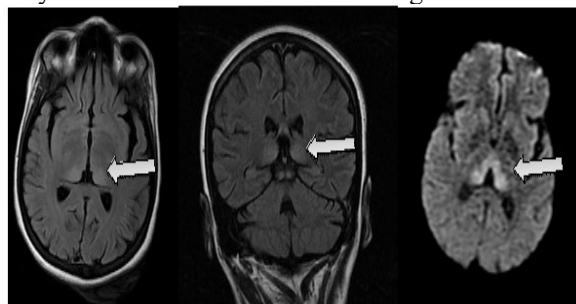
20 year old patient at 5 months of amenorrhea with altered sensorium Axial/Coronal T2 FLAIR Axial DWI reveals abnormal symmetrical hyperintensity at bilateral thalami and mammillary bodies-Wernicke's encephalopathy.
